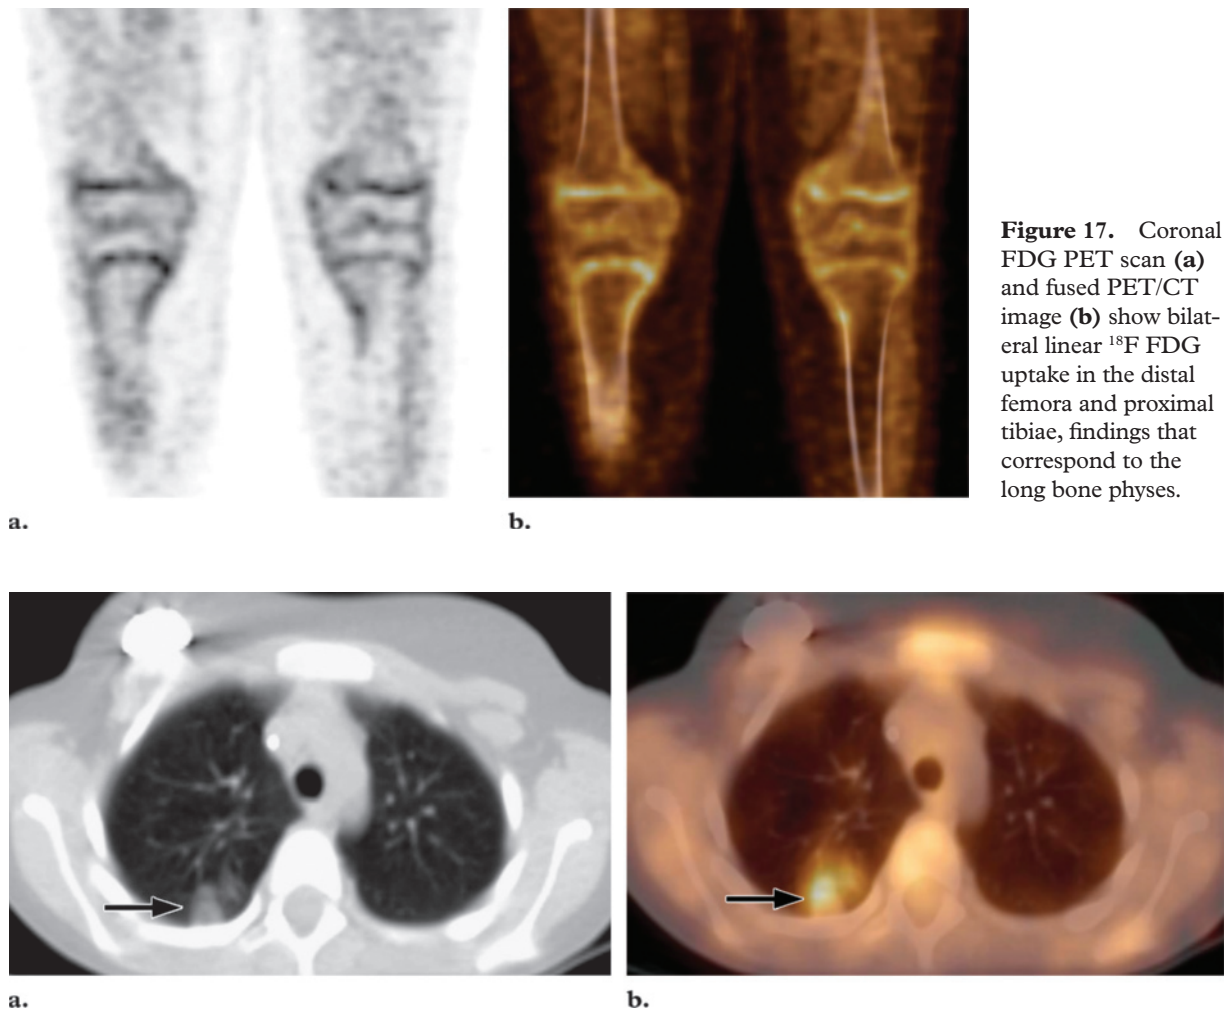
Coronal FDG PET scan (a) and fused PET/CT image (b) show bilateral linear ^{18}F FDG uptake in the distal femora and proximal tibiae, findings that correspond to the long bone physes.
